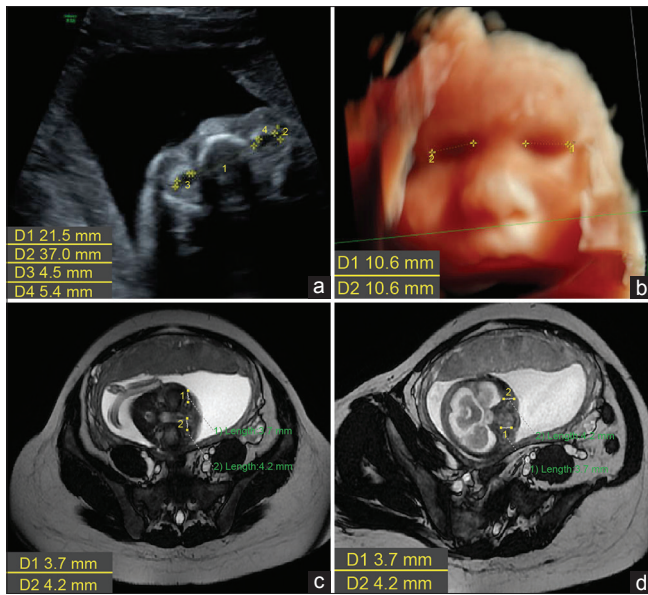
Prenatal ultrasonography (US) imaging of the second fetus. (a) Abdominal US: The inner canthal distance (D1) is long, and the outer canthal distance (D2) is normal, and the transverse ocular diameters (D3 and D4) are significantly small. (b) Three-dimensional abdominal US: the palpebral fissure lengths (D1 and D2) are significantly short. (c) Abdominal magnetic resonance imaging (MRI): the transverse ocular diameters (D1 and D2) are significantly small. (d) MRI examination: the anterior–posterior ocular diameters (D1 and D2) are significantly small
